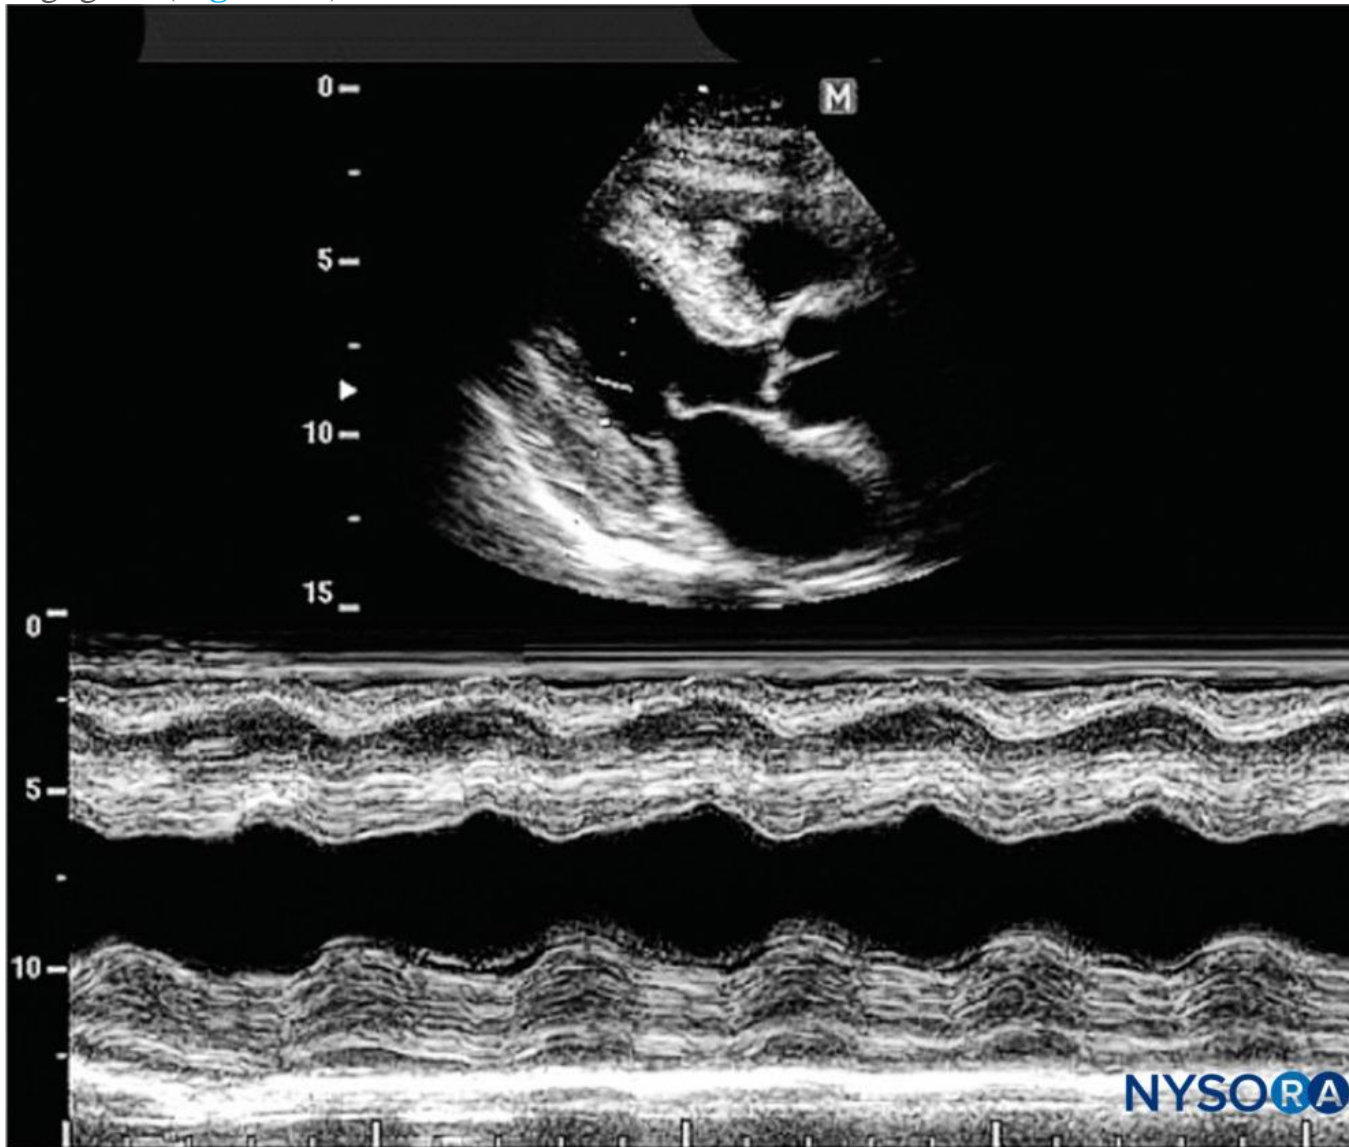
M-mode consists of a single beam used to produce an image with a motion signal. Movement of a structure can be depicted in a wavelike manner. (Reproduced with permission from Hadzic A: Hadzic's Peripheral Nerve Blocks and Anatomy for Ultrasound-Guided Regional Anesthesia, 2nd ed. New York: McGraw-Hill, Inc; 2011.)
